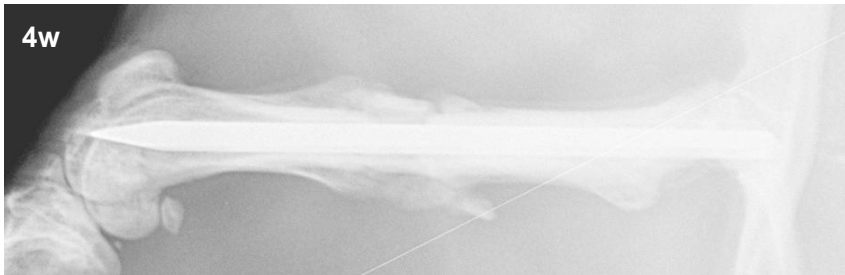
Representative radiographical images for 8 week time point. (cont.)
